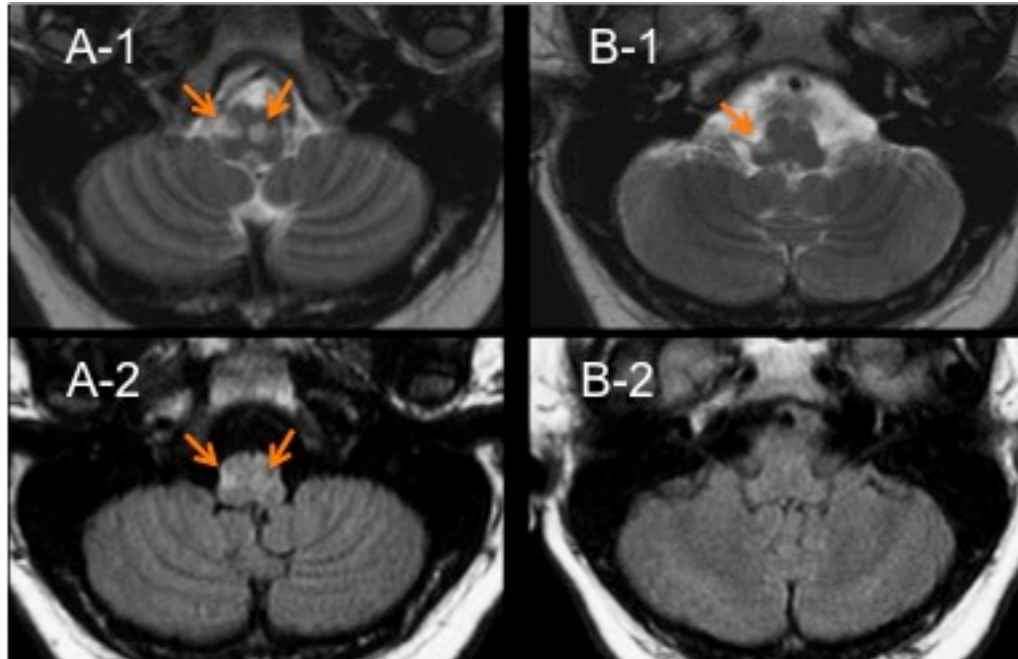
Comparison of lesion conspicuity on axial T2-weighted (top row) and FLAIR (bottom row) imaging. Two brainstem lesions (arrows) are visible on T2-weighted imaging in A-1, whereas both lesions (arrows) are more inconspicuous on FLAIR (A-2). At another level of the brainstem, the T2 lesion in B-1 (arrow) is not visible on FLAIR (B-2).
